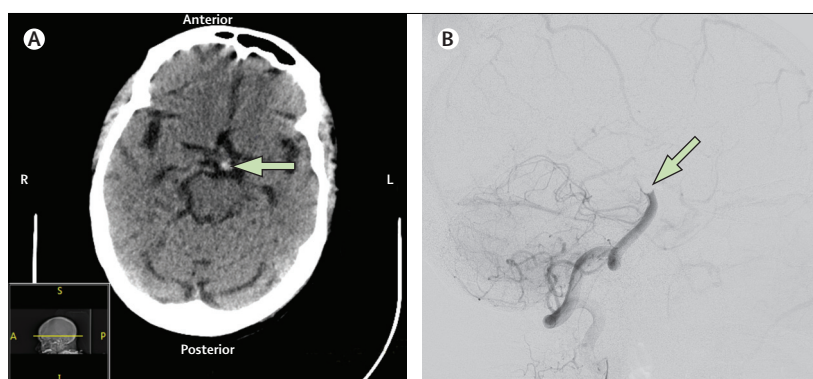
Patient who presented with evolution of motor and oculomotor findings, then rapidly decreasing level of consciousness. (A) Non-contrast brain CT shows a hyperdense basilar artery (green arrow). (B) Angiogram shows a cutoff at the distal basilar artery (green arrow).
